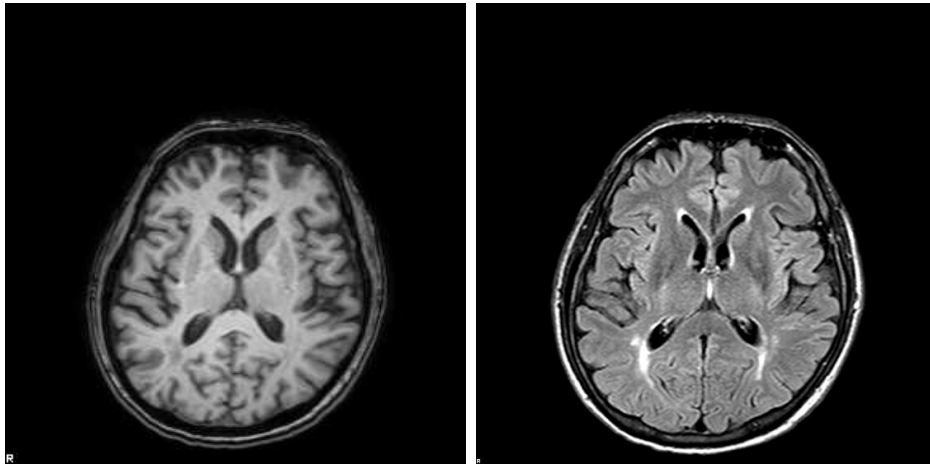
Representative MPRAGE and FLAIR Images. These images were acquired from the same subject. The image on the left was acquired with an MPRAGE sequence. The image on the right was acquired with a FLAIR sequence.
